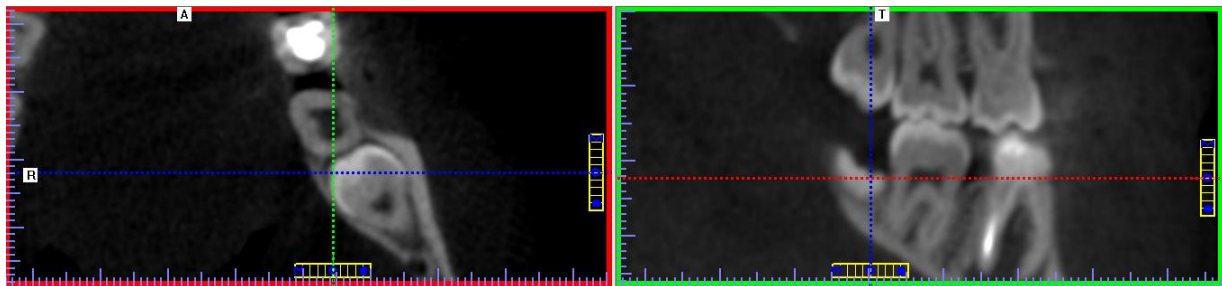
CBCT image of distal absence of caries in tooth 37 (axial and sagittal sections)
